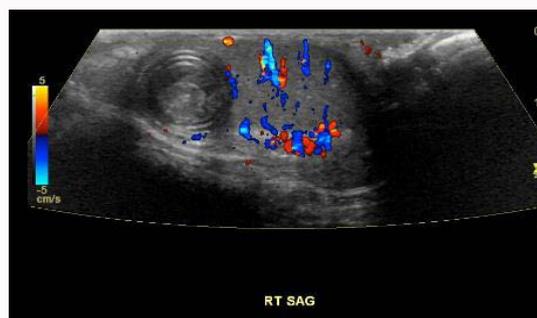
Doppler enhanced ultrasound demonstrating hypovascularity of the mass in comparison to the surrounding testicular parenchyma.
